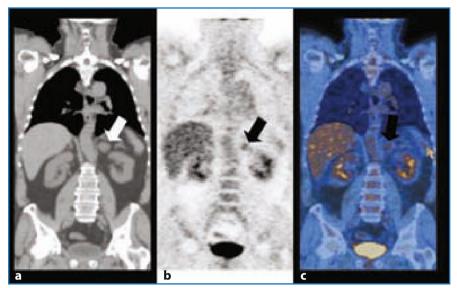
FDG-PET and PET-CT of a bilateral, small, left adrenal recurrence in patient with a history of lung cancer. PET-CT allows one to attribute a malignant nature to the small, left adrenal neoplasm (b) (*black arrow*), which had already been identified at CT (a) (*white arrow*). PET-CT reconstruction permits identification of a metastasis in the spleen parenchyma (c) (*yellow arrow*)
